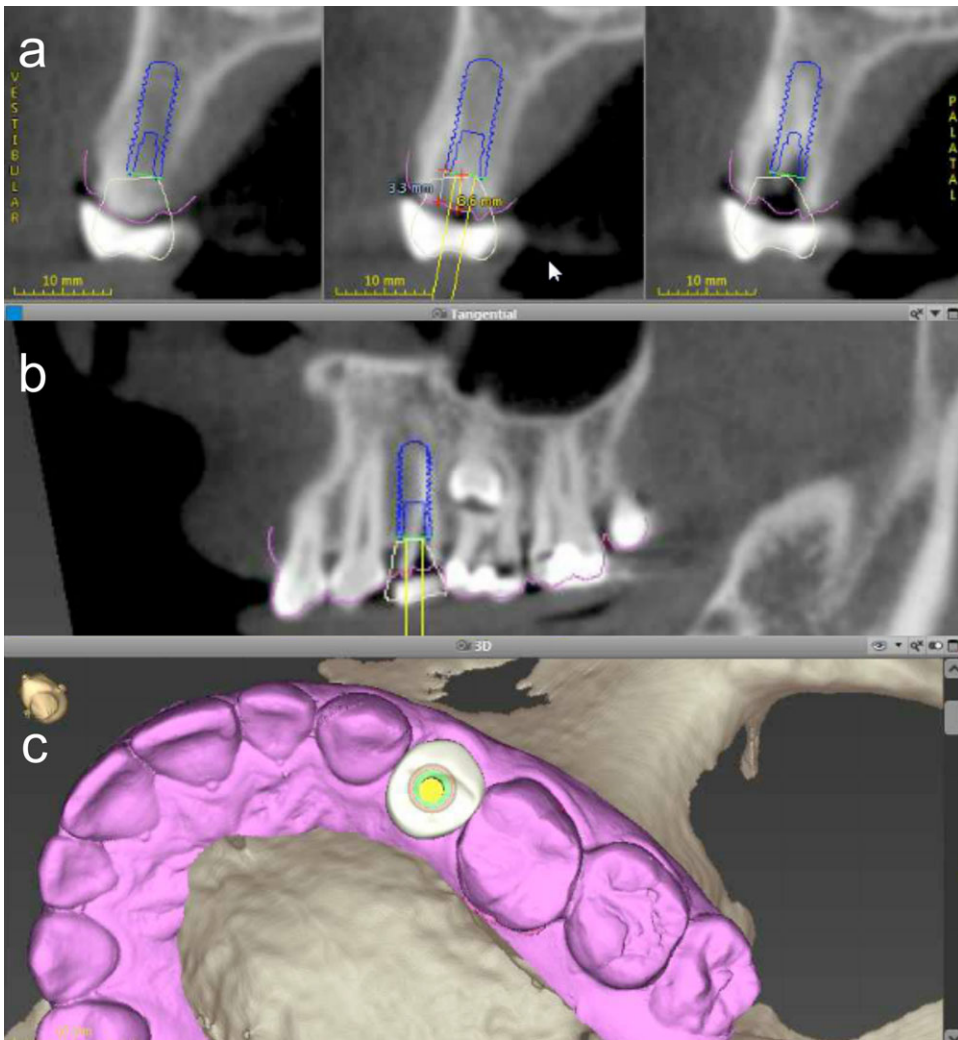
Digital planning of the dental implant position. 2a CBCT image of the implant site with virtually planned implant position. 2b The relationship of the proposed implant with respect to the adjacent teeth and tooth follicle of impacted tooth #13. 2c Superimposition of the cast and virtual setup of the provisional restoration for a screw-retained prosthesis.
